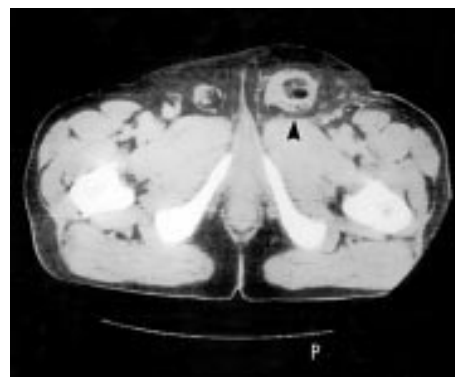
Computed tomogram demonstrating dilated loops of small bowel, and incarceration of oedematous bowel in a right inguinal hernia (arrowed).
